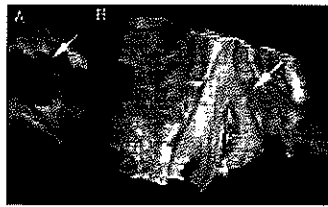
Bachmann's bundle pacing could be achieved with three-dimensional echocardiography guiding.
